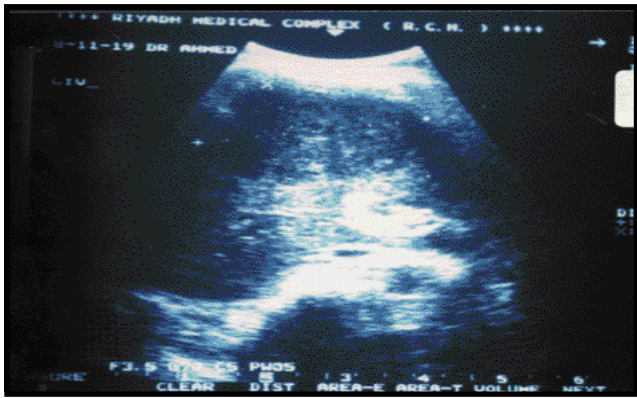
Ultrasonogram showing 8 x 7 cm hypoechoic lesion in the anterior segment of the right lobe of the liver.
